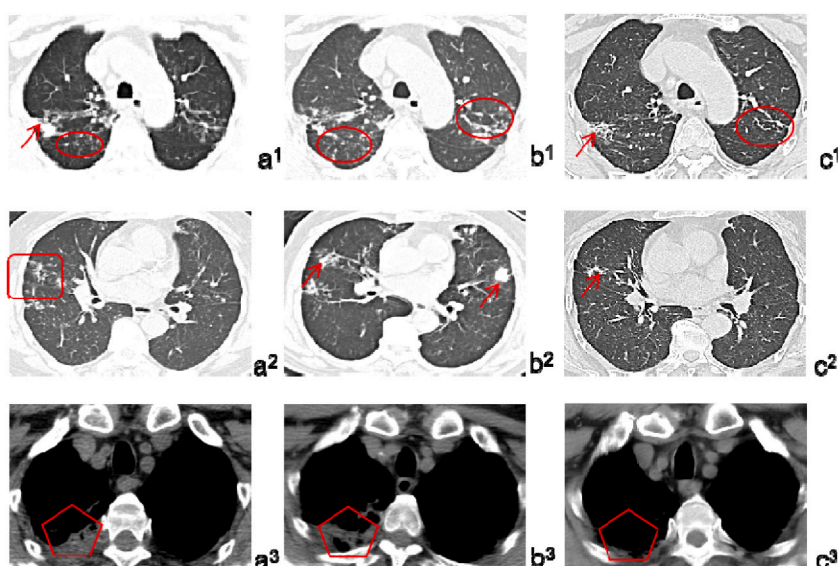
Chest CT of the current case.
